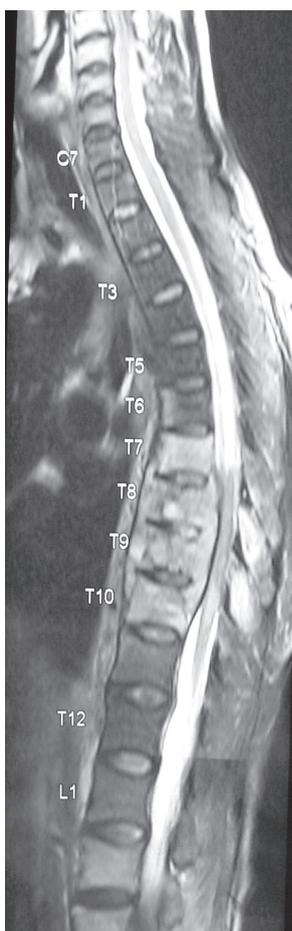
MRI: Multilevel vertebral body infiltration indicative of metastatic tumour.
